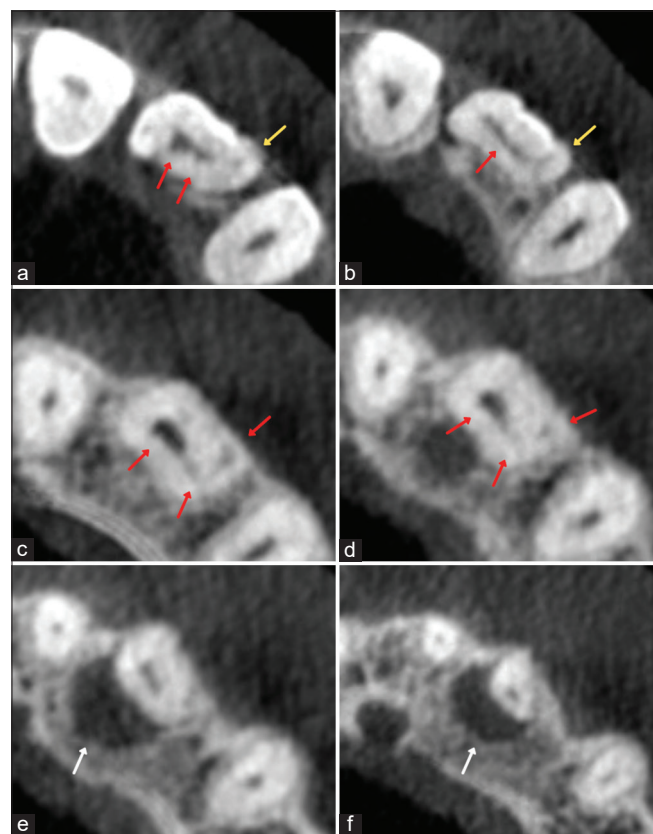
Cone-beam computed tomography serial axial sections concerning tooth #22: (a and b) Coronal one third. (c and d) Middle one third. (e and f) Apical one third. (Yellow arrow) Type I dens invaginatus in the distal portion of the crown. (Red arrows) A labiolingually thin ribbon-shaped canal system in the central portion along with interconnected two canals. (White arrow) Periapical bone destruction around the apical third of the root
